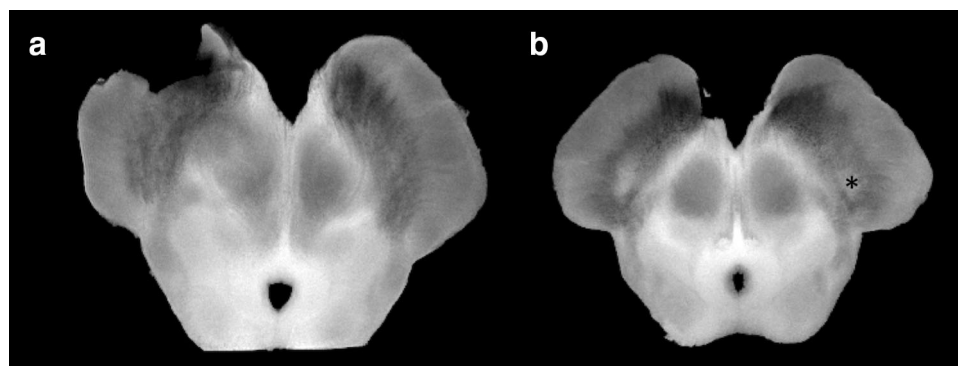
Ex vivo T_2 -weighted MRI images of the mid-mesencephalon in a PD patient (a) and healthy control (b). Nigrosome-1, marked as * on the right side of (b) is seen in the healthy control but is absent in the PD. Nigrosome-1 on the left side of (b) was not marked to
